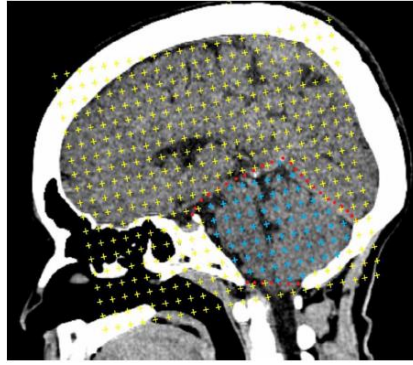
Describe the stereological method by estimation the inter cranial cavity and posterior cranial fossa on sagittal CT image by superimposition randomly the points counting grid (Ertekin, etal.2017).
